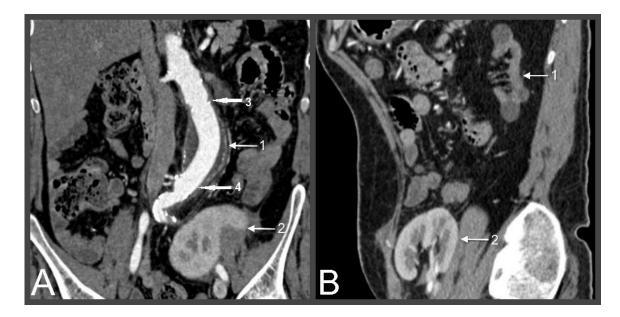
Postoperative computed tomographic angiography. A. Coronary view: Aortic aneurysm (1); Transplanted kidney (2); Proximal anastomosis (3); Distal anastomosis (4). B. Sagittal view: Wrinkled kidney (1); Transplanted kidney (2)
